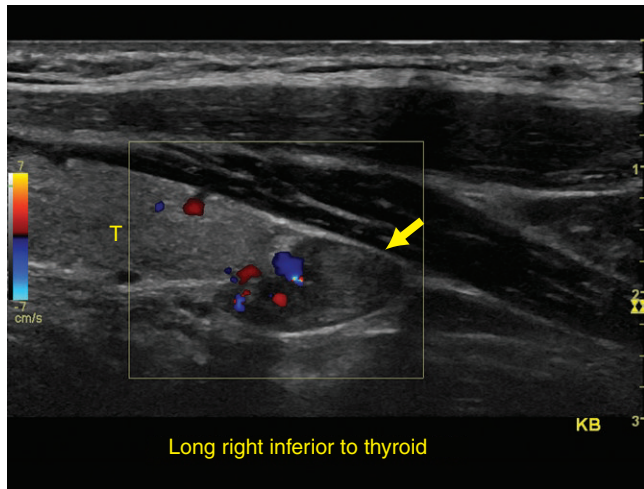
Longitudinal ultrasound through the thyroid (T) demonstrating elongated hypoechoic mass (arrow) posterior and inferior to the thyroid. There is mild increased color flow.
